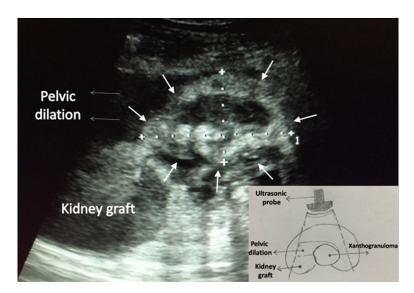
Preoperative color Doppler ultrasonography in a 51-year-old male who developed acute renal failure 6 months after receiving cadaveric renal allograft transplantation. Ultrasonography reveals a renal graft $13.5 \times 7.2 \times 7.0$ cm in size, an abnormal suprarenal echo 7.0×8.0 cm in size and pelvic dilation (1.9 cm). Arrows indicate granuloma in the renal allograft before treatment.
